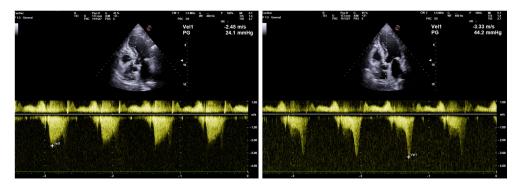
b.3. CW Doppler in a patient with obstructive HCM: left imagerecording of transvalvular aortic flow with a maximum gradient of 24.1 mmHg; right image-recording of flow in LV outflow tract with a maximum gradient of 44.2 mmHg
